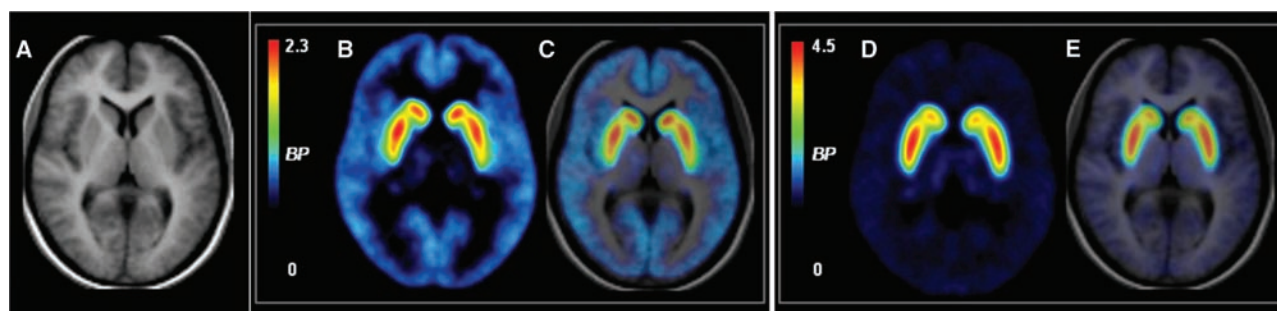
Maps of baseline D1 and D2 BP, averaged across 13 human volunteers. (A) The averaged MRI, normalized to MNI space. (B) D1 BP, measured with [¹¹C]SCH23390, averaged across participants (the bar shows absolute D1 BP). (C) Overlay of (B) on (A). (D) D2 BP, measured with [¹¹C]Raclopride, averaged across participants (the bar shows absolute D2 BP). (E) Overlay of (D) on (A).
